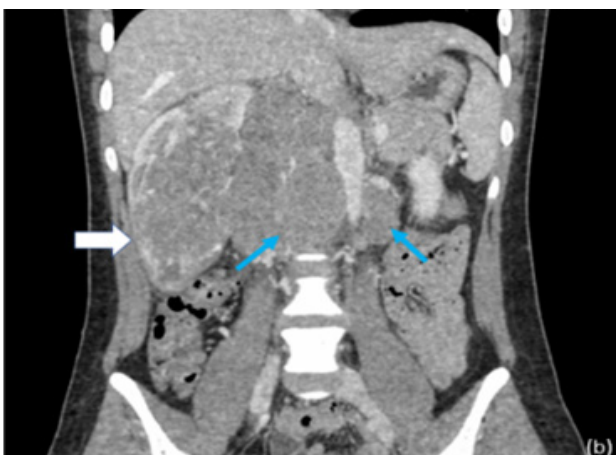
Baseline imaging - Baseline CT scan shows heterogeneous clear cell renal carcinoma (white arrow) with paraaortic lymphadenopathy (blue arrow).
